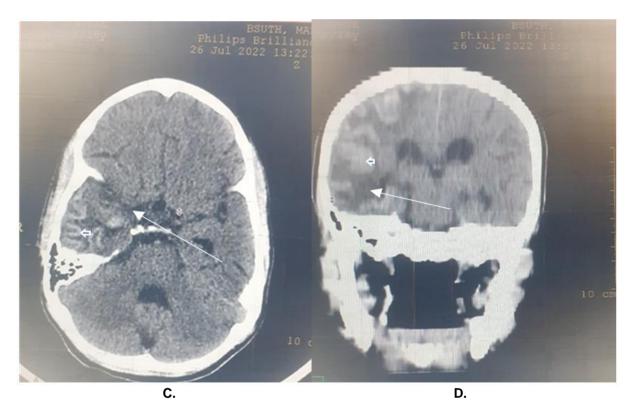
Non-Contrast Computed Tomography Scan showing extensive gyriform hyperdensities predominantly on the right cerebral hemisphere involving the frontal, parietal, occipital and temporal lobes and extending above the level of the lateral ventricles (arrow heads). There is associated marked perilesional oedema (straight arrows) but no midline shift
